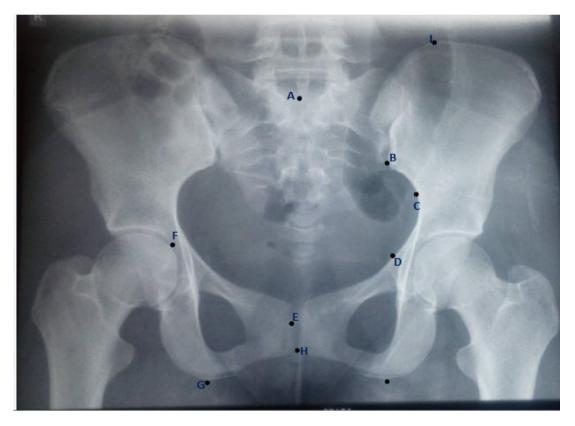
Shows the Landmarks of Normal Antero-posterior Pelvic Radiograph in Adult Nigerians.
